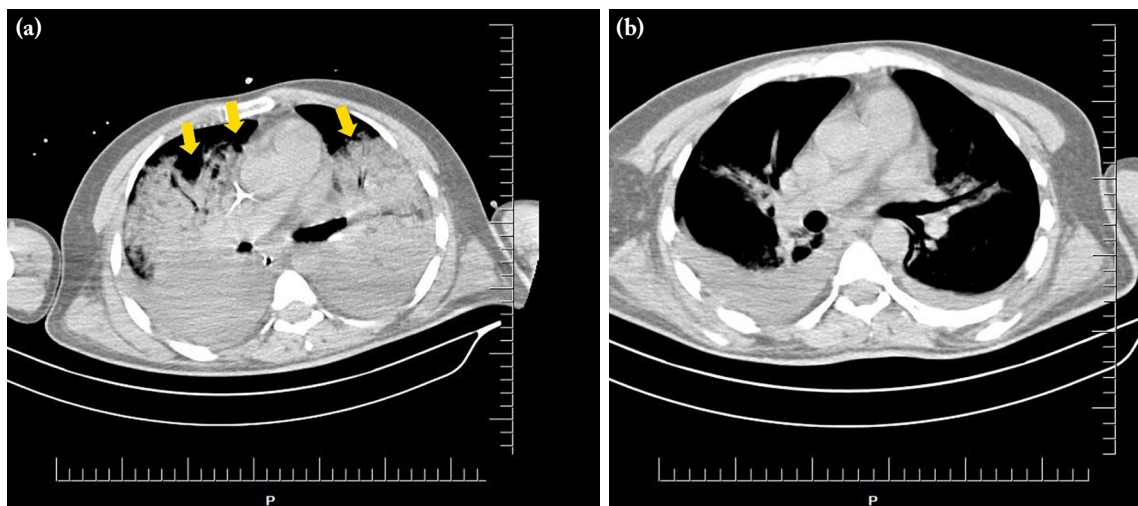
(a) Bilateral lung infiltration, ground glass appearance, and ARDS on thorax computed tomography (yellow arrows). (b) Control thorax computed tomography shows regression of ARDS findings.
